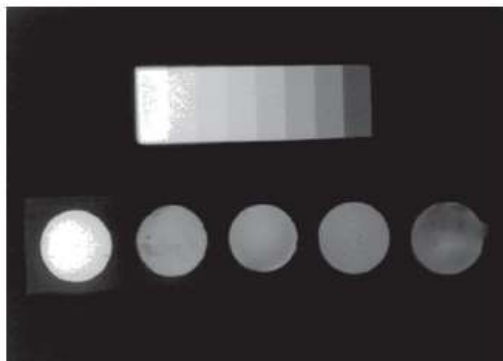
Radiograph showing the radiopacity of Sealer
